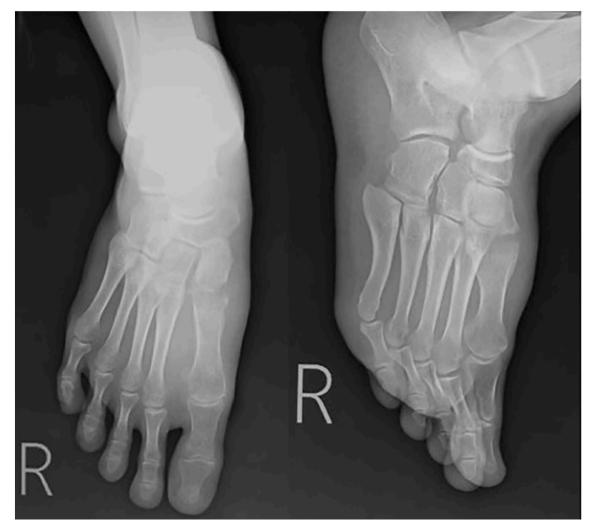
Right foot x-ray taken on 1st admission to the clinic, destruction at the base of 1st metatarsal bone is noted.
